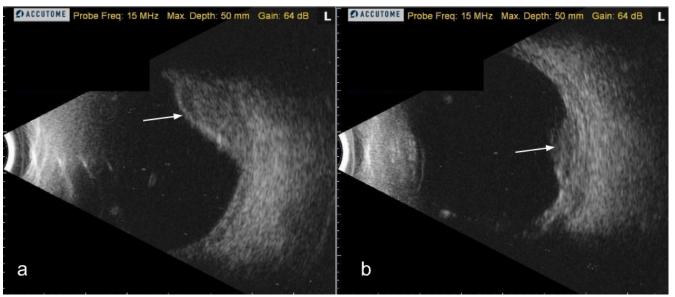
a-b. Ultrasound B-scan of the left eye on postoperative day 3 showed the limited, non-appositional suprachoroidal hemorrhage as dense with hyper-echogenicity (white arrows).
